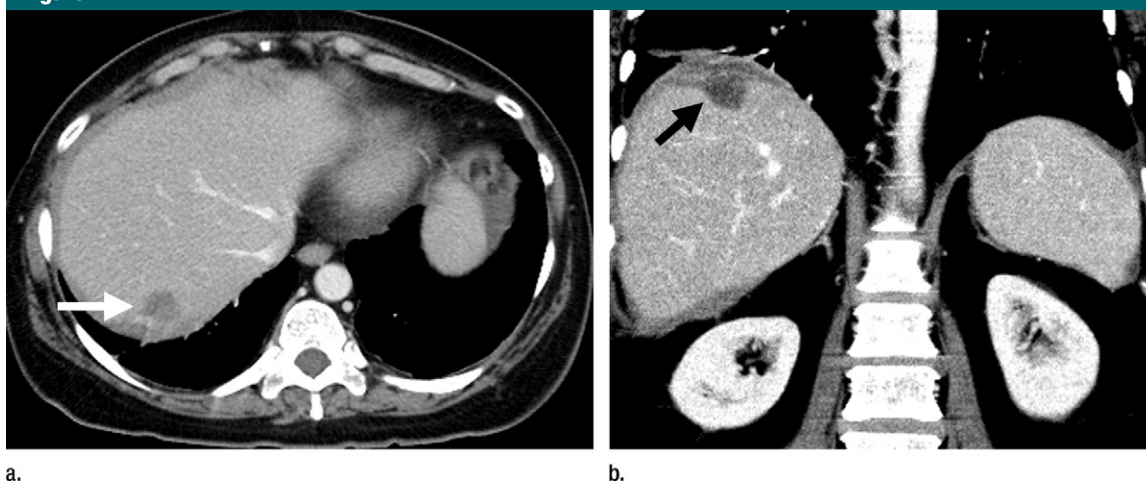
(a) Axial and (b) coronal contrast-enhanced CT scans in a 57-year-old patient with serous adenocarcinoma. It may be difficult to distinguish between LPI (arrow) and hematogenous on axial image (a) but coronal image (b) helps demonstrate LPI with extension into the liver parenchyma, with agreement between all reviewers.
